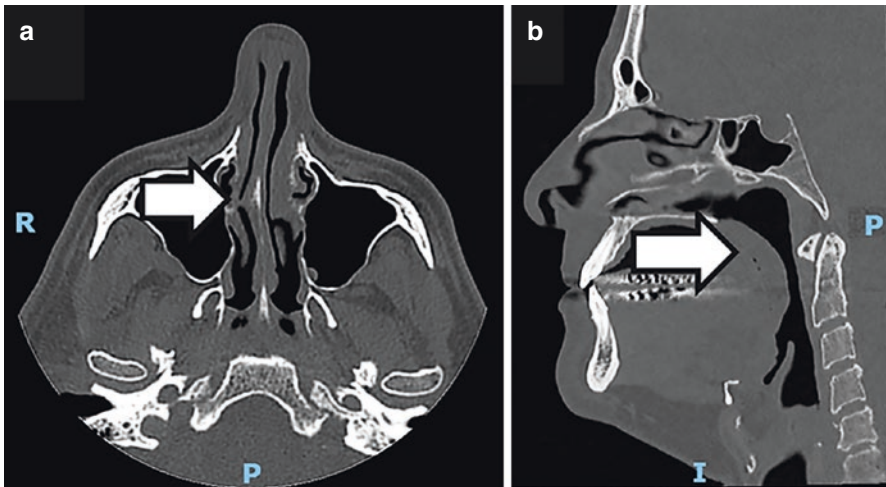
Computed tomography of sinuses and face showing (white arrows): (a) Nasal septum inclined to the left in the anterior cartilaginous portion and deviated to the right in the other portions and (b) Elongated soft palate with reduced pharyngeal air column caliber. *R* right, *P* posterior, *I* inferior. Reprinted with permission from A.C.G
